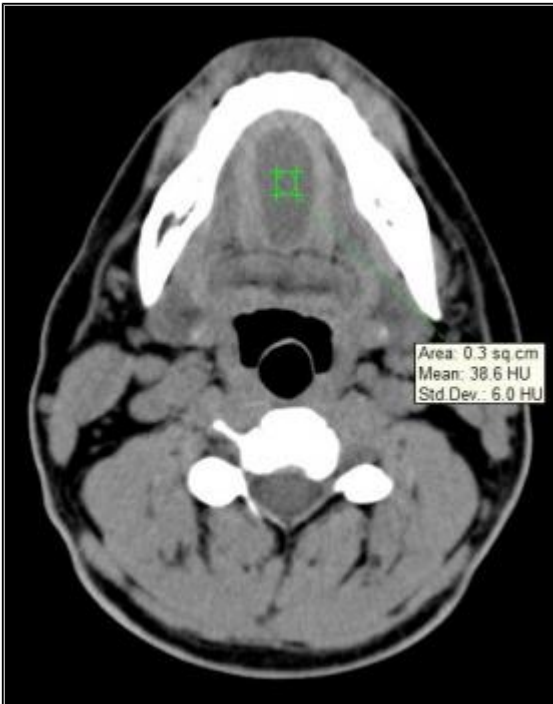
Pre-contrast CT
